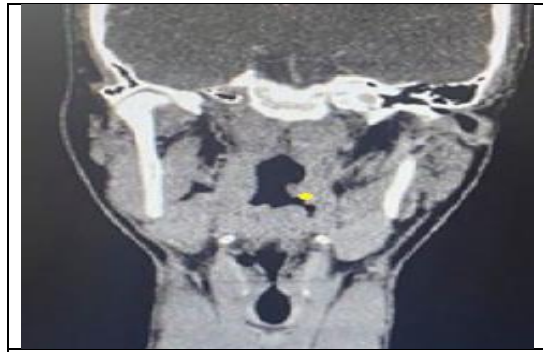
The tumor in the left palatine tonsil seen on the coronal CT scan.
